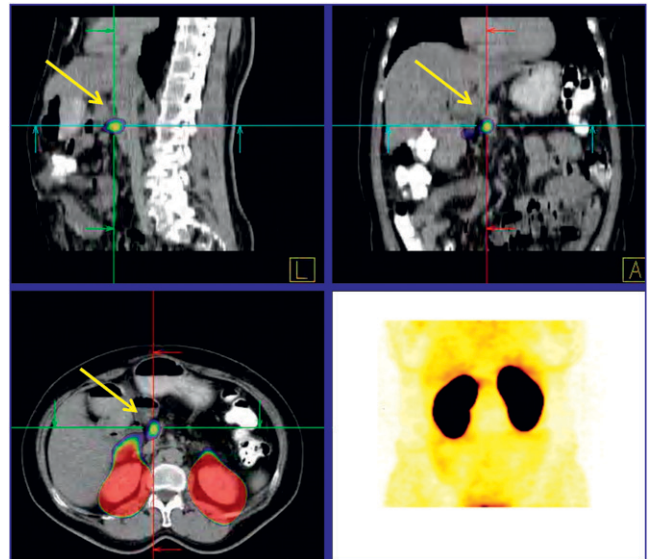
62-y-old woman with hypoglycemia in whom SPECT/CT, MR, and somatostatin receptor scintigraphy were negative but $\text{Lys}^{40}\text{NH}_2(\text{Ahx})\text{-HYNIC-}^{99\text{m}}\text{Tc}$ imaging clearly showed focal uptake in the insulinoma.
